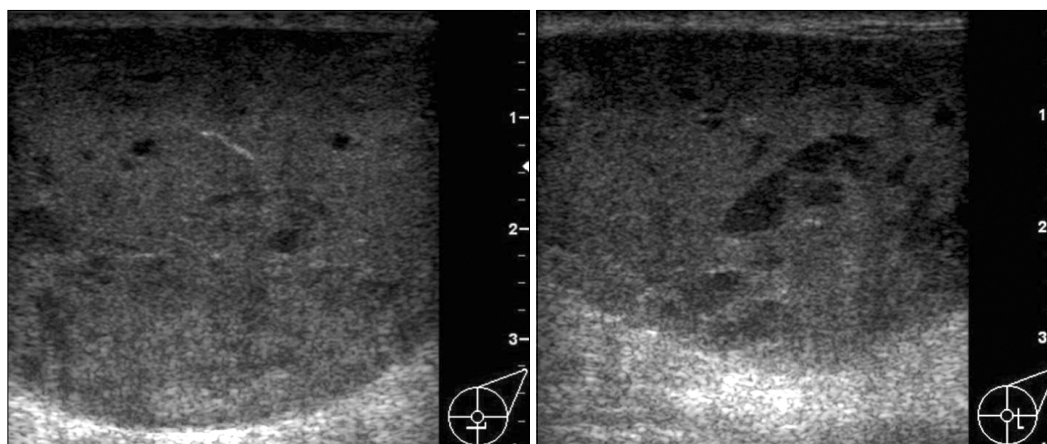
Breast sonography showed solid, hypoechoic with heterogeneous internal echoes and well demarcated border.
